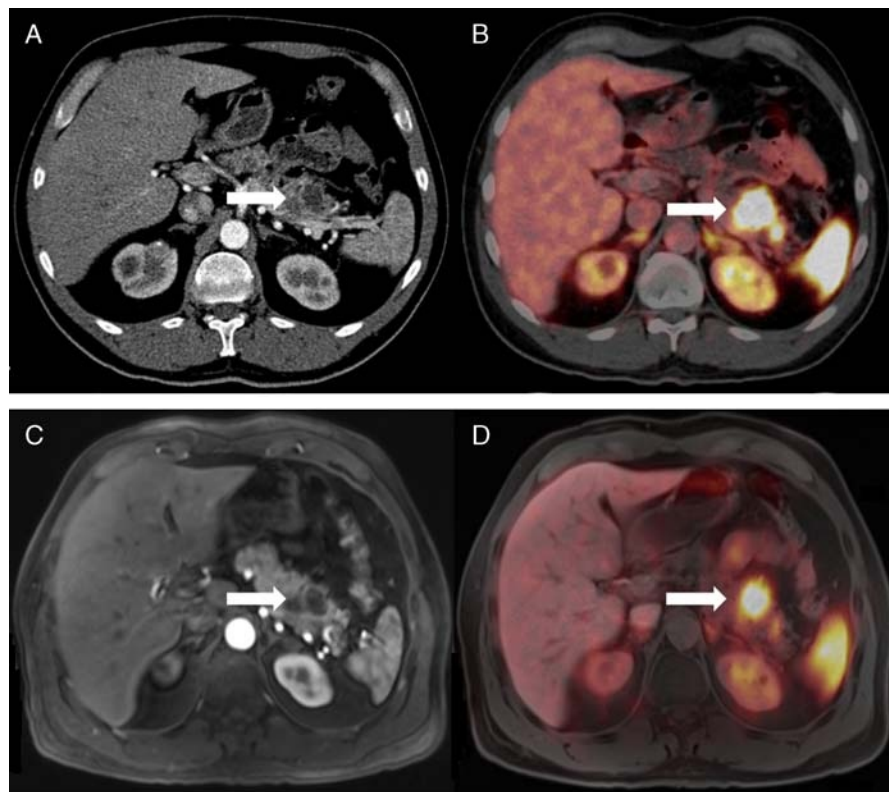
Primary NET (G1) in the body and tail of the pancreas (arrow) depicted in PET/CT (A, arterial contrast medium phase; B, corresponding fused PET/CT image) and in PET/MRI (C, T1 VIBE, arterial contrast medium phase; D, corresponding fused image) in a 46-year-old man.
